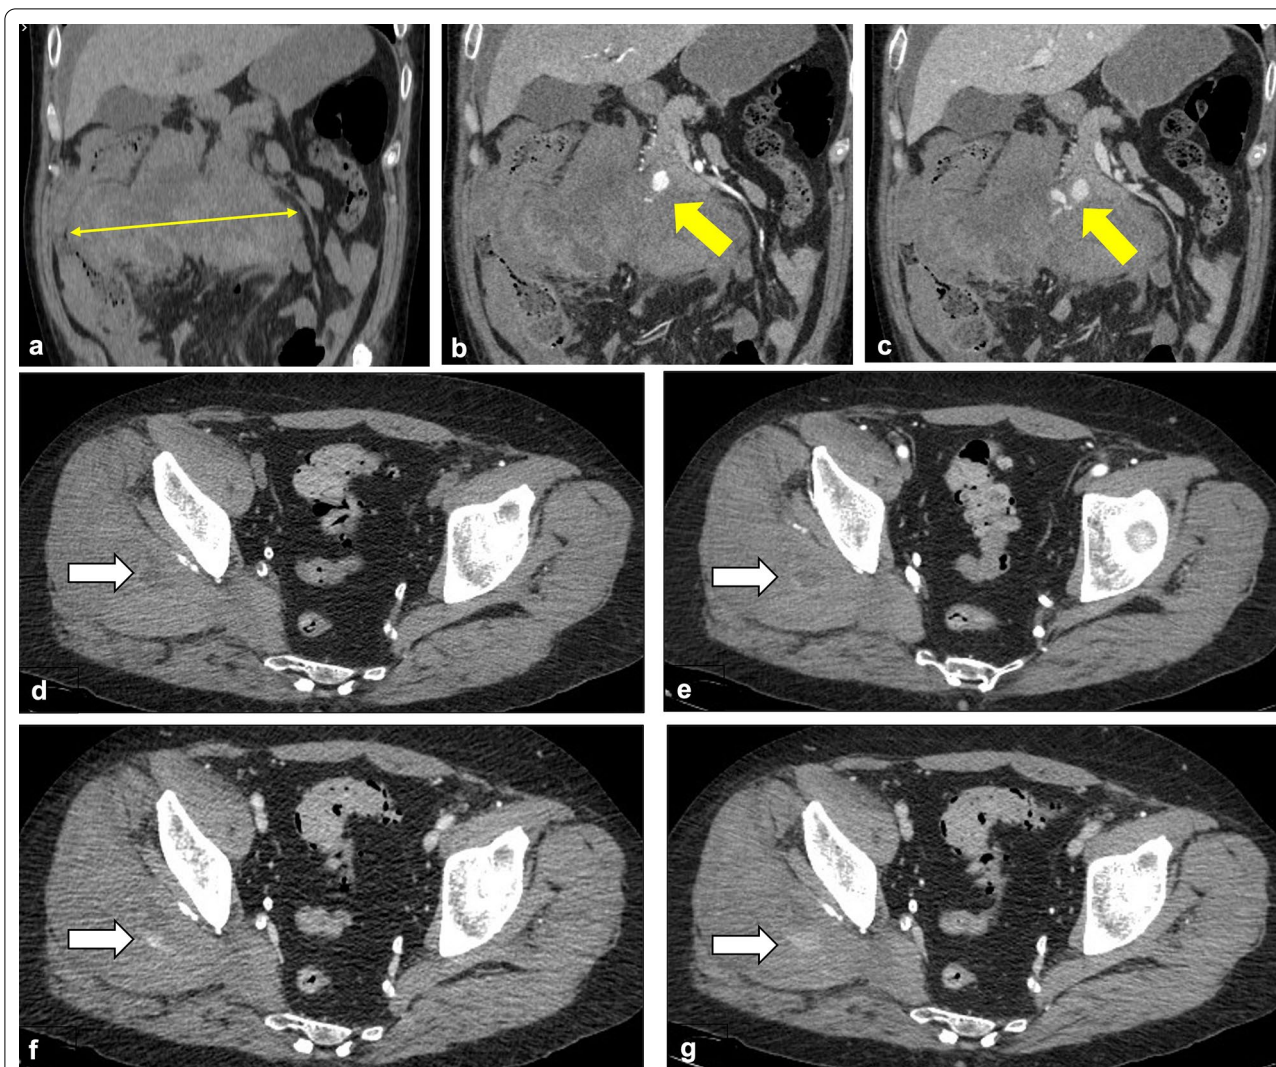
Representative images of hemorrhagic complications in the abdomen. CT scans from COVID-19 patients with hemorrhagic complications. A, B, C Coronal contrast-enhanced CT images of a 62-year-old patient show a large retroperitoneal hematoma (thin yellow arrow, A), with arterial contrast blush from pancreaticoduodenal artery (yellow arrows, B and C). D, E, F, G Axial contrast-enhanced CT scans of a 54-year-old patient revealed a ill-defined hematoma within the right gluteus medium muscle (white arrow in D), with active bleeding in arterial, venous and delayed phase (white arrows, E, F and G)
